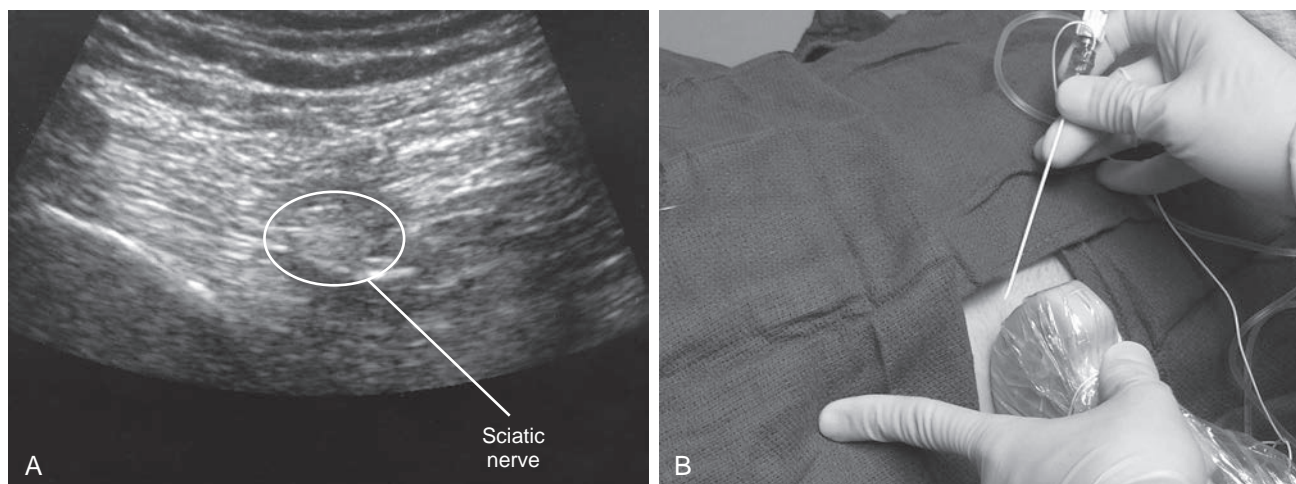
Peripheral nerve block of sciatic nerve. A, Ultrasound image of the sciatic nerve during a peripheral nerve block. B, Image of the needle and ultrasound transducer during a peripheral nerve block.
